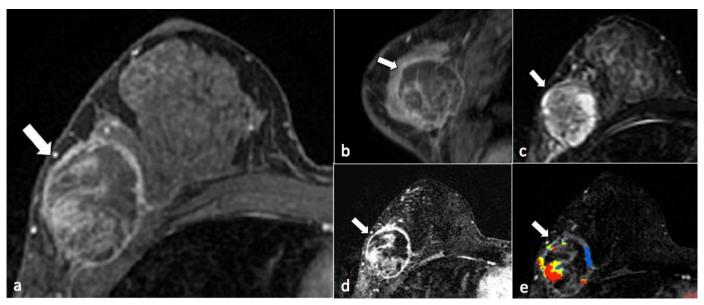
29 year-old female with metaplastic breast carcinoma, 2 weeks after core needle biopsy diagnosis. FINDINGS: Pretreatment breast MRI shows the metaplastic breast carcinoma (white arrow) presenting as a 4.6 cm oval rim-enhancing mass with central heterogeneous enhancement with no clear fat plane between the mass and pectoralis major muscle. It demonstrates short tau inversion recovery (STIR) hyperintensity, and suspicious Type III rapid washout kinetics. TECHNIQUE: a) Axial 1.5T MRI 1.6mm slice thickness, TR 5.5, TE 2.6, 10.4ml IV omniscan at 90 seconds post contrast administration b) sagittal reformatted non-subtraction image, 1.5T MRI, reformatted at 0.7mm slice thickness, TR 5.5, TE 2.6, 10.4ml IV omniscan at 90 seconds post contrast administration c) axial STIR image 1.5T MRI 4mm slice thickness, TR 3000, TE 67, no contrast. d) axial T1 subtraction post contrast fat-saturated 90 second post-contrast administration axial image, 1.5T MRI, 1.6mm slice thickness e) axial T1 subtraction with overlying angiomap, T1 fat-saturated 90 second post-contrast administration axial image, 1.5T MRI, 1.6mm slice thickness e) axial T1 subtraction with overlying angiomap, T1 fat-saturated 90 second post-contrast administration axial image, 1.5T MRI, 1.6mm slice thickness e) axial T1 subtraction with overlying angiomap, T1 fat-saturated 90 second post-contrast administration axial image, 1.5T MRI, 1.6mm slice thickness angiomap of red-Type III rapid washout kinetics, yellow - Type II rapid plateau kinetics, blue - Type I rapid persistent kinetics.
